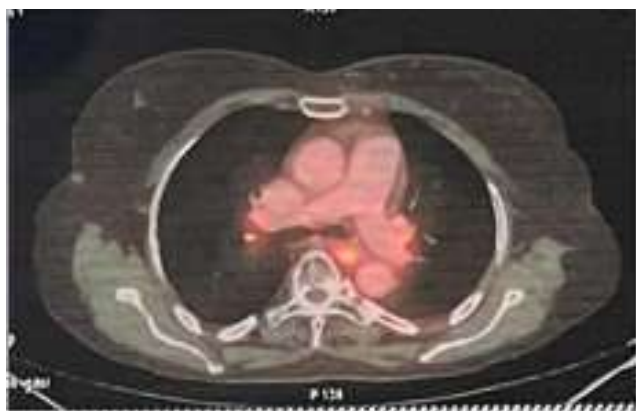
PET CT image showing Esophageal primary
